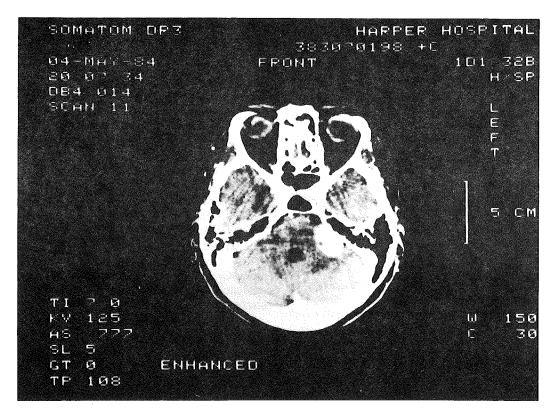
Preoperative CT scan showing lesion in left cerebellopontine angle region.
